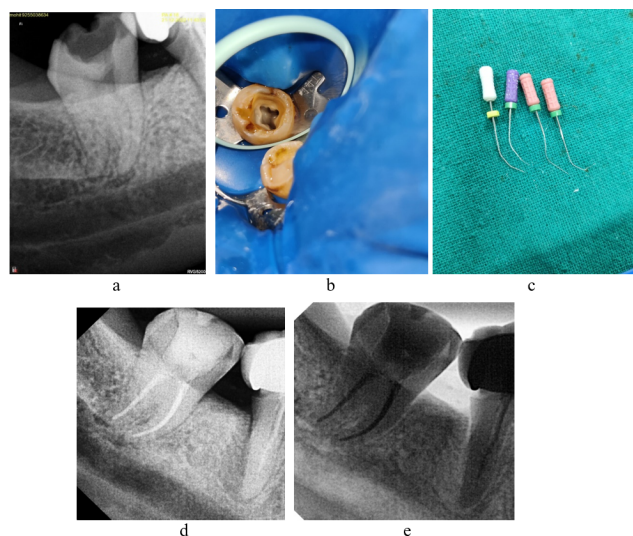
a); Preoperative radiograph; b): Access cavity preparation under rubber dam isolation; c): Precurved hand files; d & e): Postoperative Radiographs
